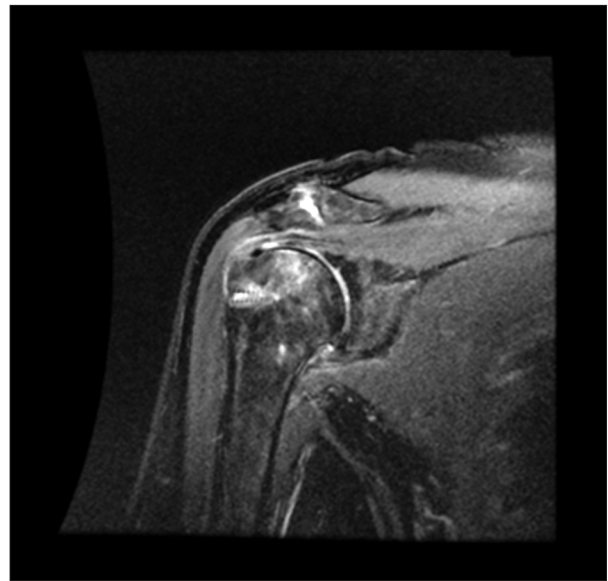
Postoperative imaging of rotator cuff injury in a representative patient. Postoperative coronal oblique T2-weighted fat-suppressed magnetic resonance imaging of the same shoulder obtained following arthroscopic rotator cuff repair. The image demonstrates successful restoration of the supraspinatus tendon continuity with intact suture anchors visible within the greater tuberosity footprint region. This postoperative imaging confirms adequate tension and positioning of the repaired rotator cuff, which is essential for successful rehabilitation outcomes.
